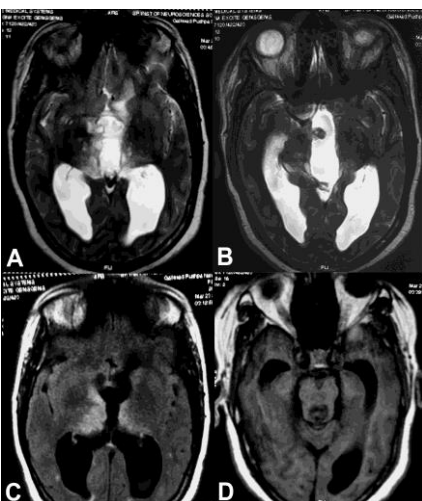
MRI brain T1W, T2W and Flair axial images showing bilateral thalamic tumor with blockage of the aqueduct and associated hydrocephalus.
